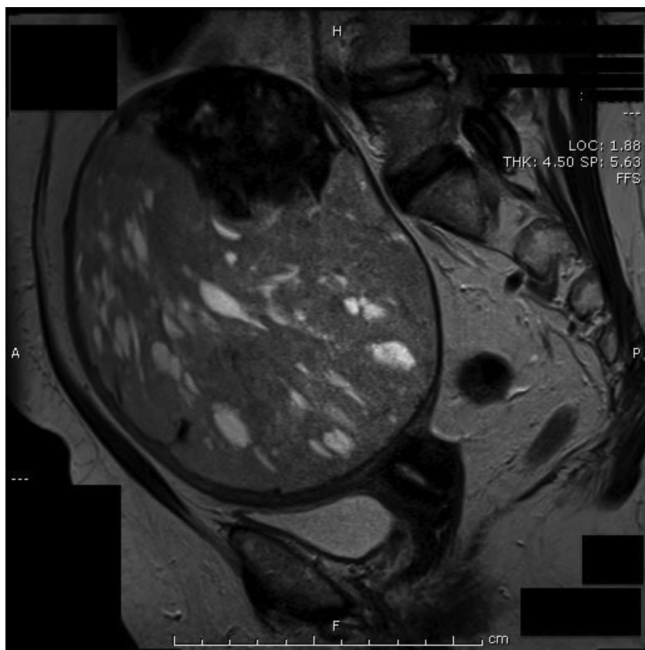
Pelvic MRI of uterine leiomyosarcoma. The endometrium is obscured by the large mass, with evidence of cystic degeneration and bleeding within the lesion.
